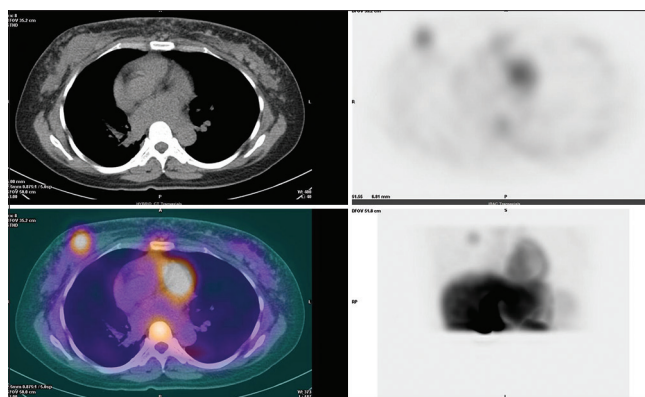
(a) Low-dose computed tomography images provide adequate anatomic detail on the nodular masses seen in both breasts. (b) An axial slice taken from the single-photon emission computed tomography data set shows a dense focus of tracer accumulation and another less intense and more diffuse area of uptake in the right and left breasts, respectively. (c) The fused images showed that the breast masses are sestamibi-avid, with the right tumor showing greater uptake. Sternal uptake is at the same level as that in the vertebral body. (d) The maximum intensity projection is a three-dimensional rendering of the single-photon emission computed tomography dataset
